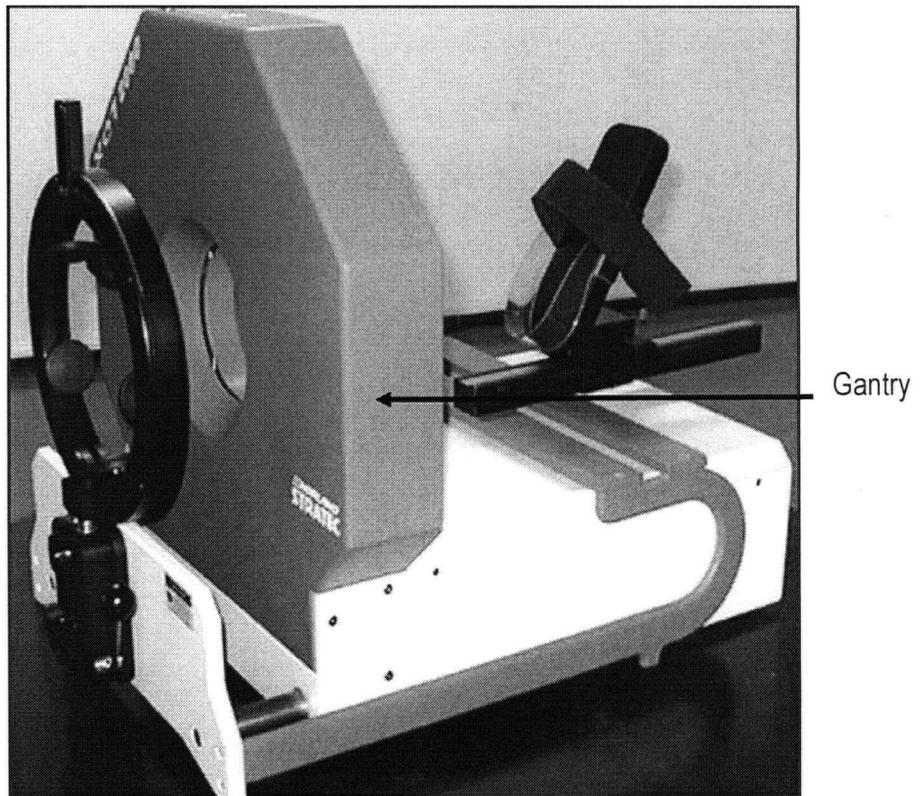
Peripheral quantitative computed tomography: Norland XCT 2000.
